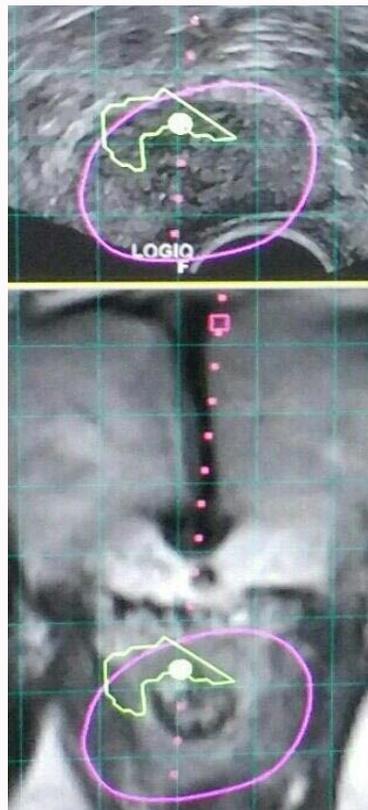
UroNav fusion of ultrasound (top image) and MRI (bottom image).
